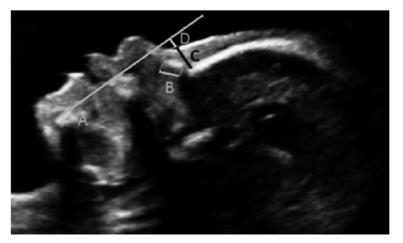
Ultrasound image of a fetus with Down syndrome at 21+3 weeks' gestation, showing the maxillamandible line (A), nasal bone length (B), prenasal thickness (C) and the 'd' measurement (D). The prefrontal space ratio was calculated by dividing D by C, and the prenasal thickness-to-nasal bone length ratio was calculated by dividing C by B. Reproducibility of the fetal profile measurements was assessed in all cases, using stored images (or volumes when available). Markers were measured by two examiners (F.I.V. and E.J.P.) who were blinded to gestational age and to previous measurements, but not to karyotype. Images were chosen at random at different gestational ages, with at least 3 weeks between the two assessments when performed by the same examiner. Only a single measurement was used for the analysis relating to detection rates for DS. Data were compared to reference values derived from our previous studies on euploid fetuses^{11,12,14}, which found that NBL and PT increased with gestation from 3.3 mm at 15 weeks to 9.6 mm at 33 weeks (NBL= $-6.927 + (0.83 \times GA) - (0.01 \times GA^2)$ and from 2.3 mm at 15 weeks to 6.1 mm at 33 weeks (NBL= $-6.927 + (0.83 \times GA) - (0.01 \times GA^2)$ and from 2.3 mm at 15 weeks to 6.1 mm at 33 weeks (PT = $0.212 \times GA - 0.873$), respectively. The PT-NBL ratio and PFSR were stable throughout gestation, with a mean of 0.61 (95th percentile, 0.80) and 0.97 (5th percentile, 0.55), respectively. Measurements of NBL and PFSR below the 5th percentile were considered abnormal, and for PT and PT-NBL ratio values above the 95th percentile were considered abnormal. Multiple of the median (MoM) values were calculated for PT and NBL to correct for gestational age. In cases of absent nasal bone, NBL was set at 1 mm for statistical analysis and was considered to be below the 5th percentile.
